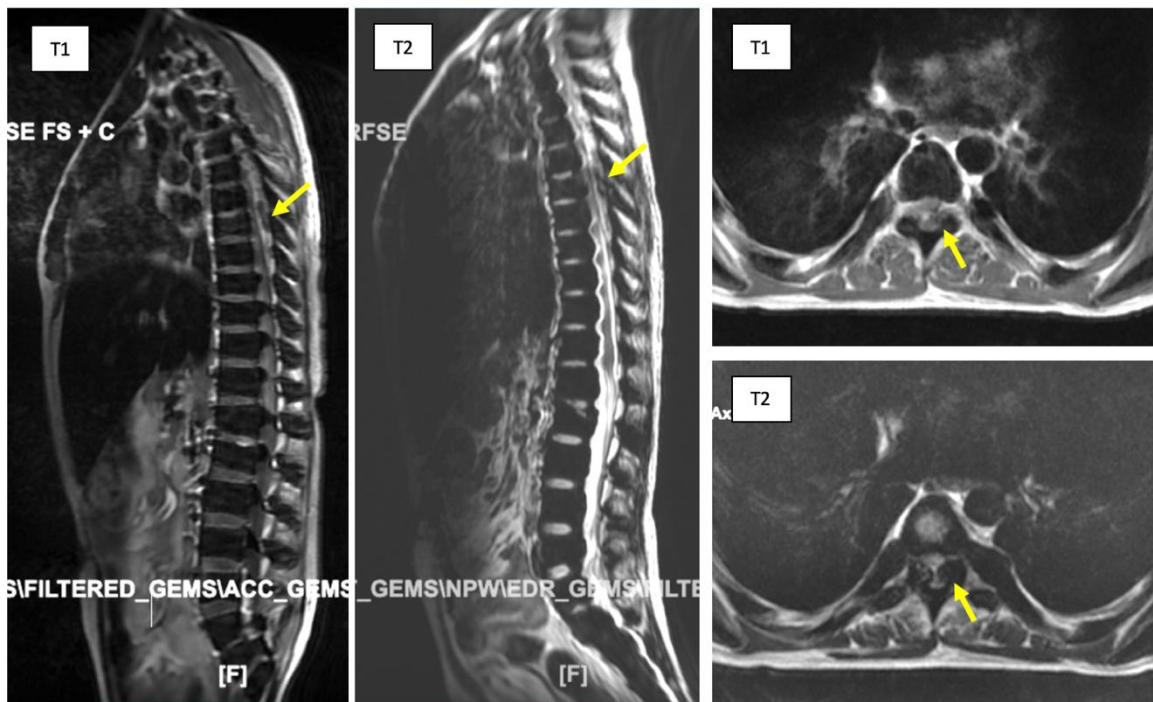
Spine MRI. Intradural extramedullary hypointense lesions at Th 6 and Th 7 levels (yellow arrow).
